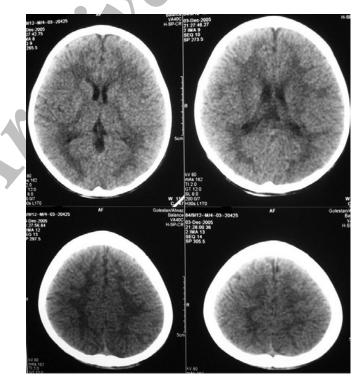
The second brain CT scan revealed a dramatic decrease of the brain edema
